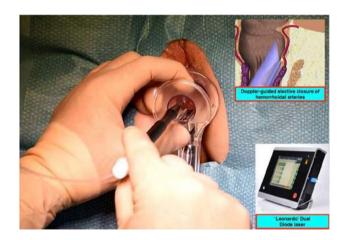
Laser closure of hemorrhoidal arteries identified by Doppler
